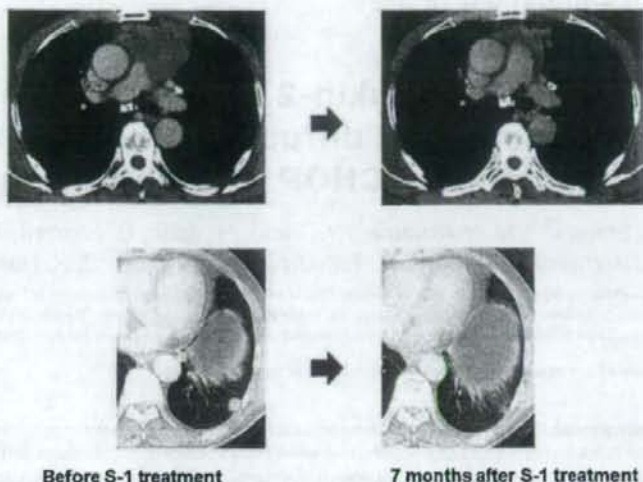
CT findings obtained before and 7 months after S-1 treatment.
